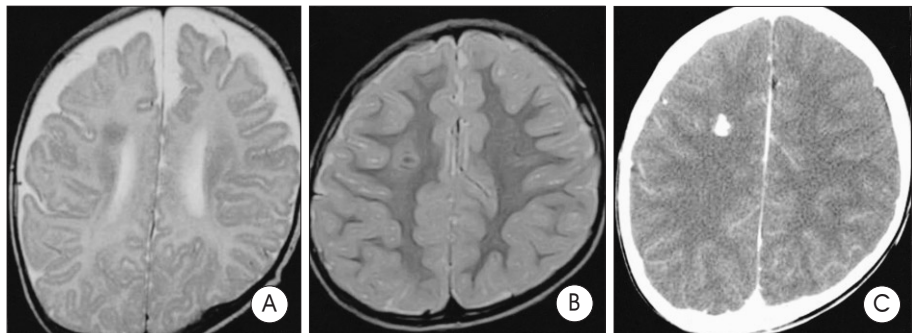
Initial(3 month after birth, May 1996) brain magnetic resonance(MR) image showing a small periventricular lesion(A), which is changed as a more prominent calcified lesion in follow-up MR image (4 year-old, September 2000)(B) and recent computed tomography(7 year-old, February 2003)(C).
